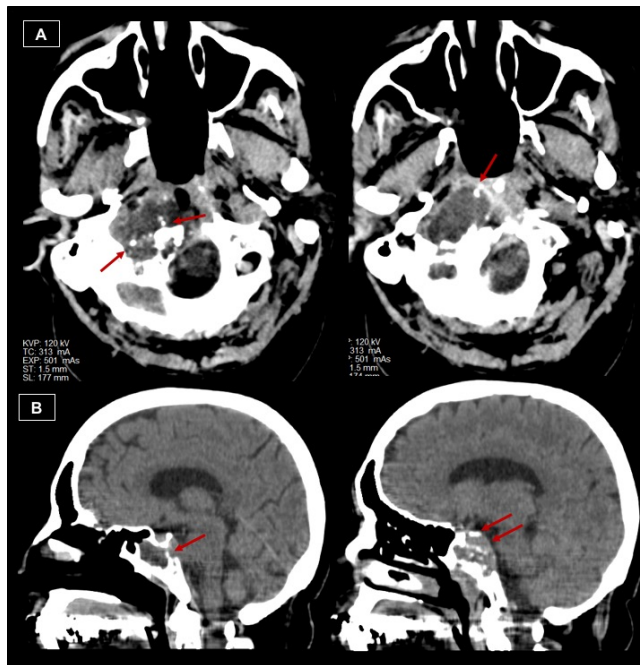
Axial (A) and sagittal (B) CT scan slices of two patients with chordomas presenting with intrinsic calcifications/bone sequestrations (red arrows).
